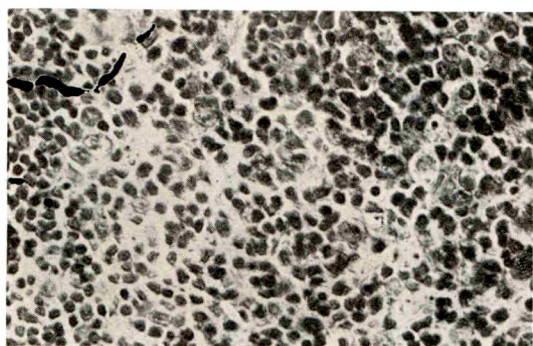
Lymph node seven days after exposure to a small roentgen dose ( $1/3$  S.U.D.). There is some increase in connective tissue. An occasional phagocyte is seen.
